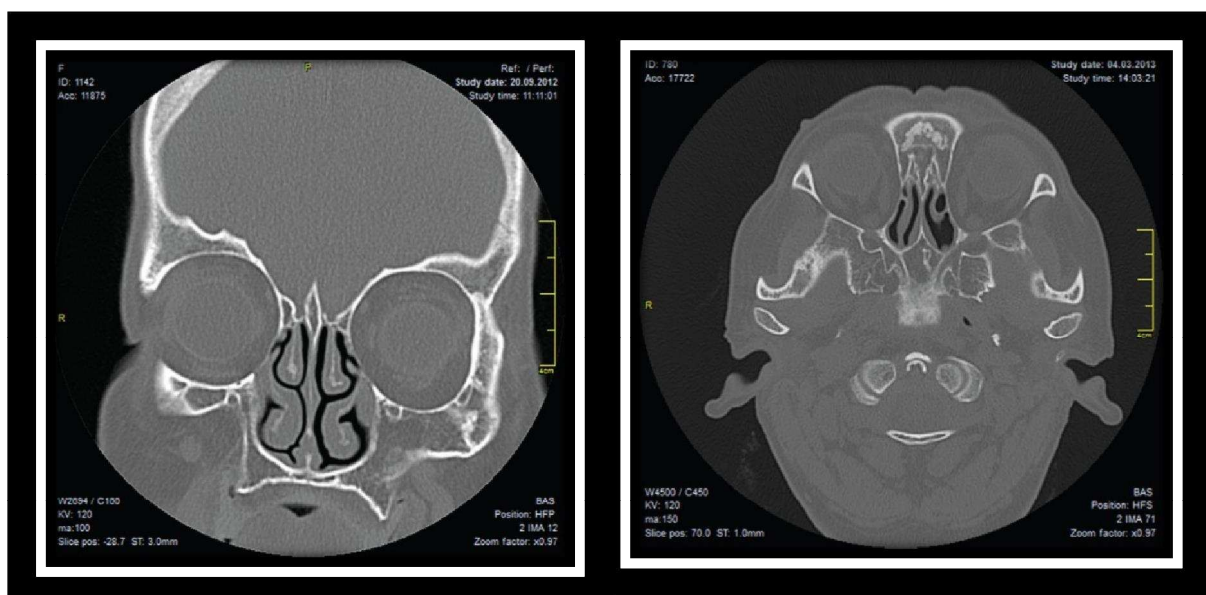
CT scans showing total agenesis of all paranasal sinuses with normal appearing nasal septum and conchae. Taken from: Korkmaz H, Korkmaz M. Total aplasia of the paranasal sinuses.. *Allergy & rhinology* 2013;4(2):e105-9.
